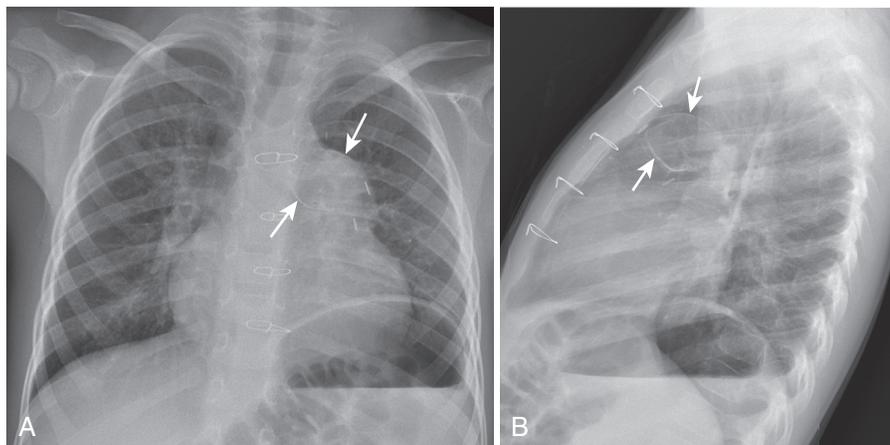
PA (A) and lateral (B) chest radiographs in a patient with truncus arteriosus. There is dilation of the main pulmonary artery, which is calcified (arrows) as a marker of chronic pulmonary arterial hypertension.
